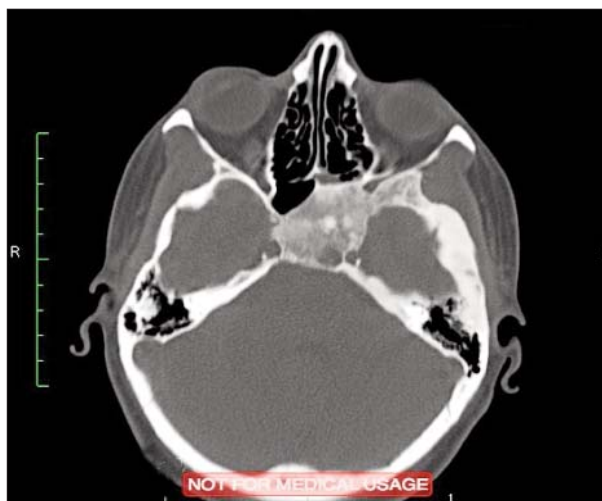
CT, transverse view – Spheno-ethmoidal fibrous dysplasia
